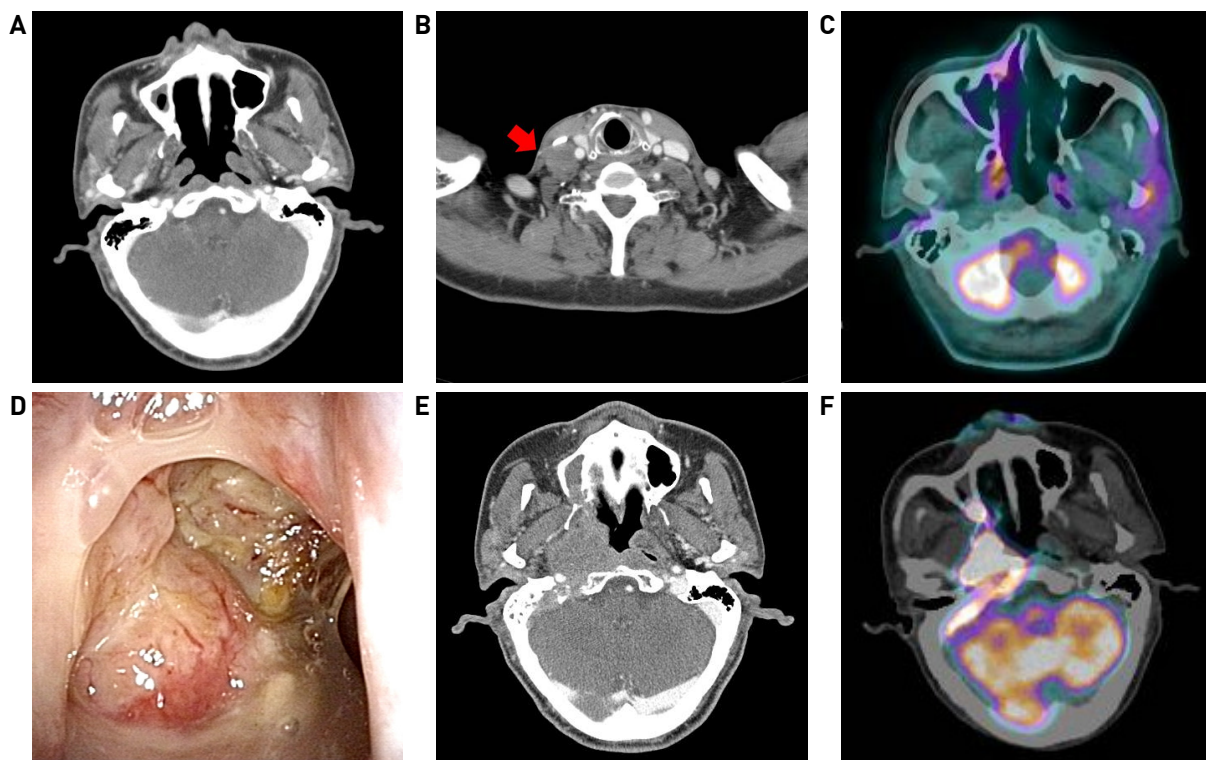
Case 1. Before detection of right nasopharyngeal cancer, normal CT on the nasopharynx(A) and right metastatic neck mass(B) and normal PET-CT image on nasopharynx(C). After detection of nasopharynx cancer, endoscopic finding of right nasopharyngeal cancer(D), right nasopharyngeal mass on CT(E) and PET-CT(F) images.
